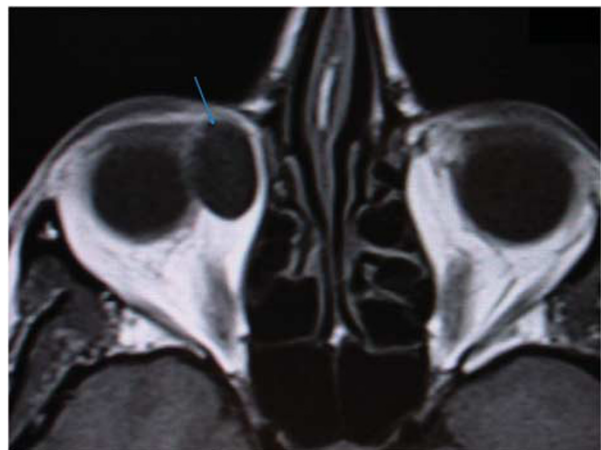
Orbital MRI Scan. Arrow shows a giant hidrocystoma (17.5-mm diameter) abutting the eyeball medially in the orbit.
